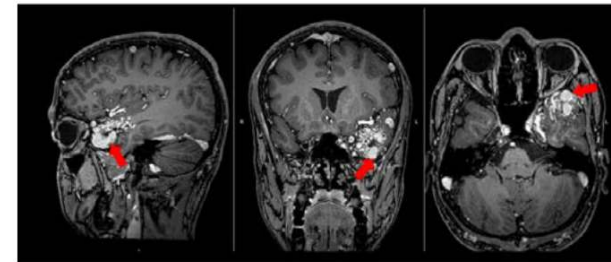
T1-weighted brain MRI showing the AVM nidus at the left temporal pole with a venous aneurysm (red arrows).
